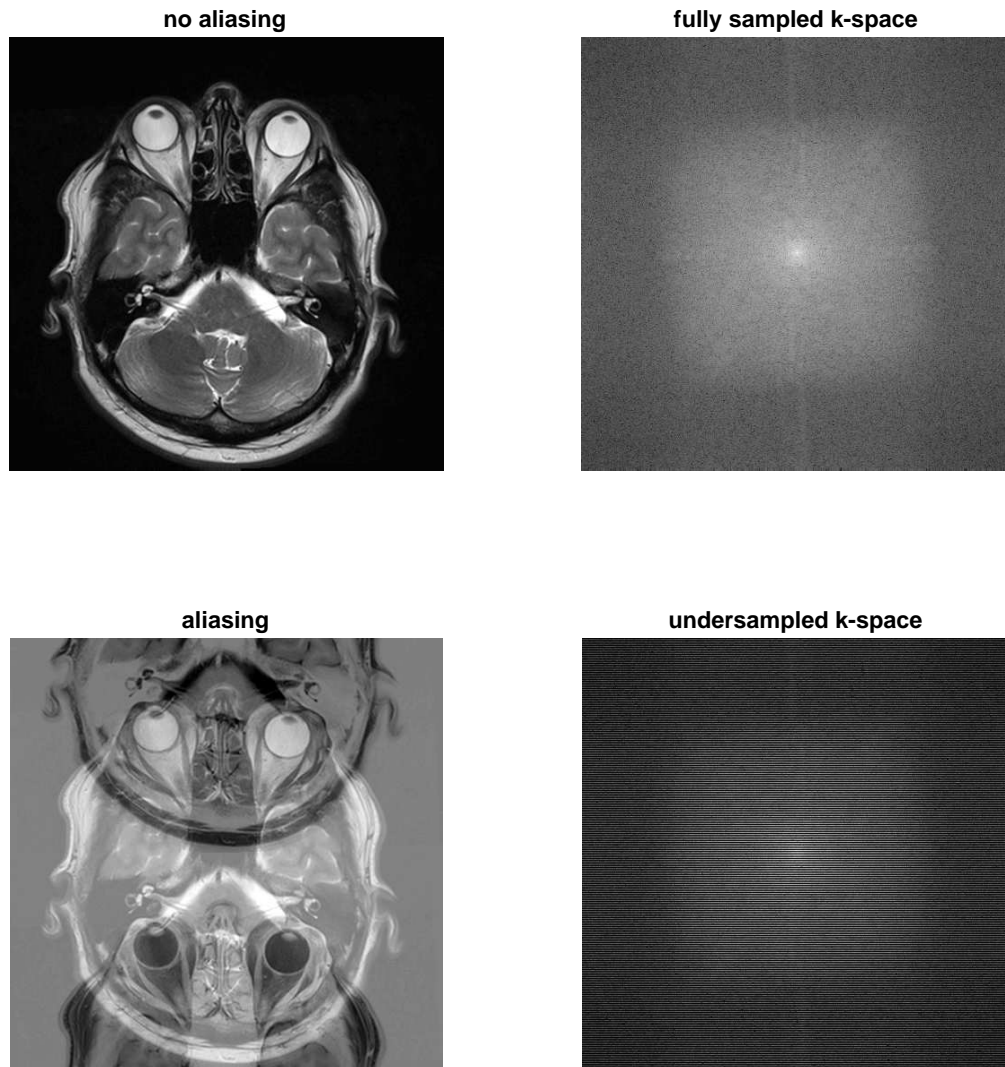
MRI reconstruction example showing undersampled k-space data can cause aliasing in final image reconstruction. Top left panel shows an image reconstructed from fully sampled k-space data with no aliasing; Top right panel shows fully sampled k-space data; Bottom right panel shows the undersampled k-space created by choosing every other row of the fully sampled k-space; Bottom left panel shows an image reconstructed from undersampled k-space displayed in bottom right panel.
